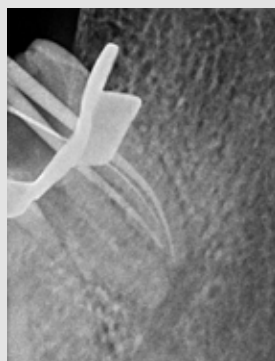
Radiographic confirmation of middle mesial canal.
